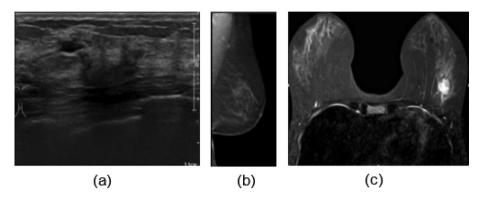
The examples of medical imaging modalities for breast tissues: (a) ultrasound, (b) mammogram, and (c) MRI.
